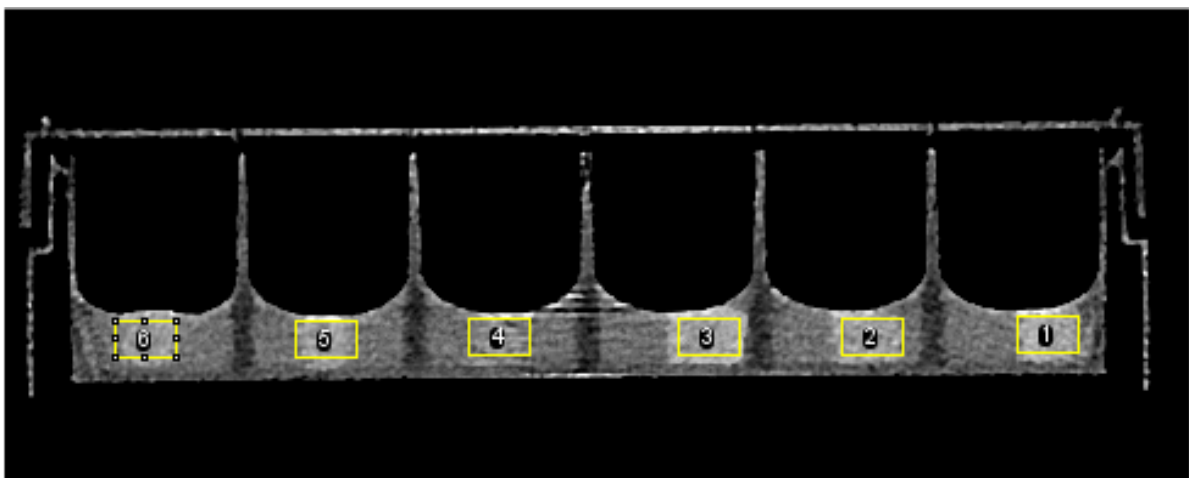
Analysis of CT images with ImageJ
